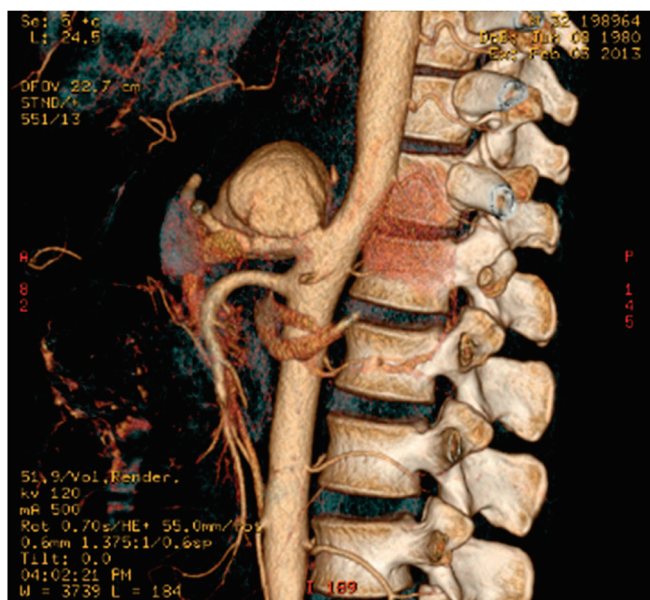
Reconstruction of CT angiography demonstrating a massive aneurysm of the celiac trunk.
